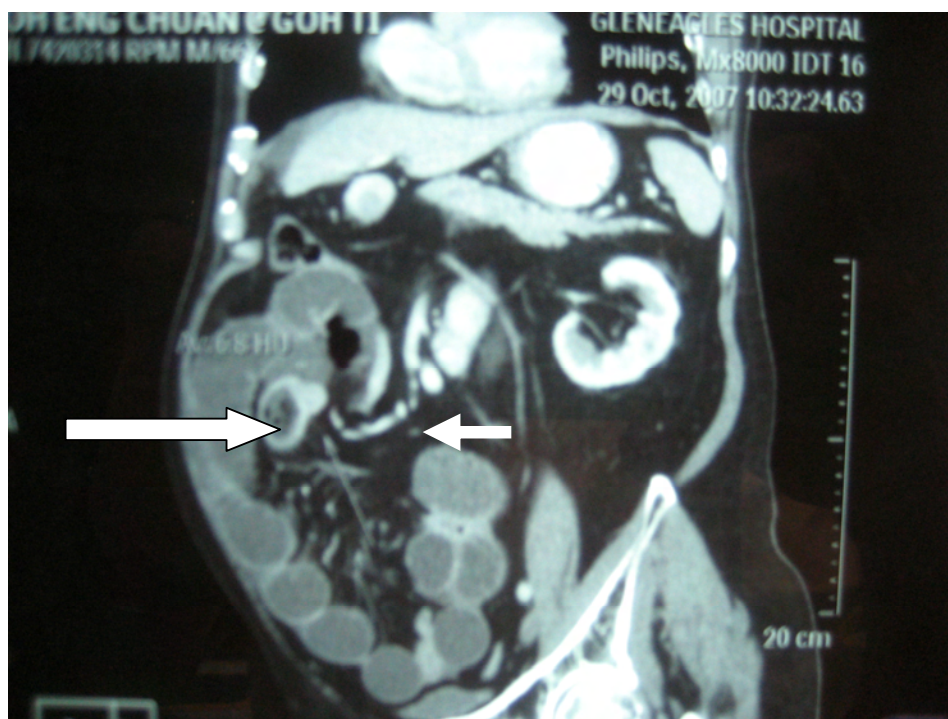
CT scan showing distended proximal ileum, mass lesion (long arrow) and collapsed distal ileum (short arrow)
